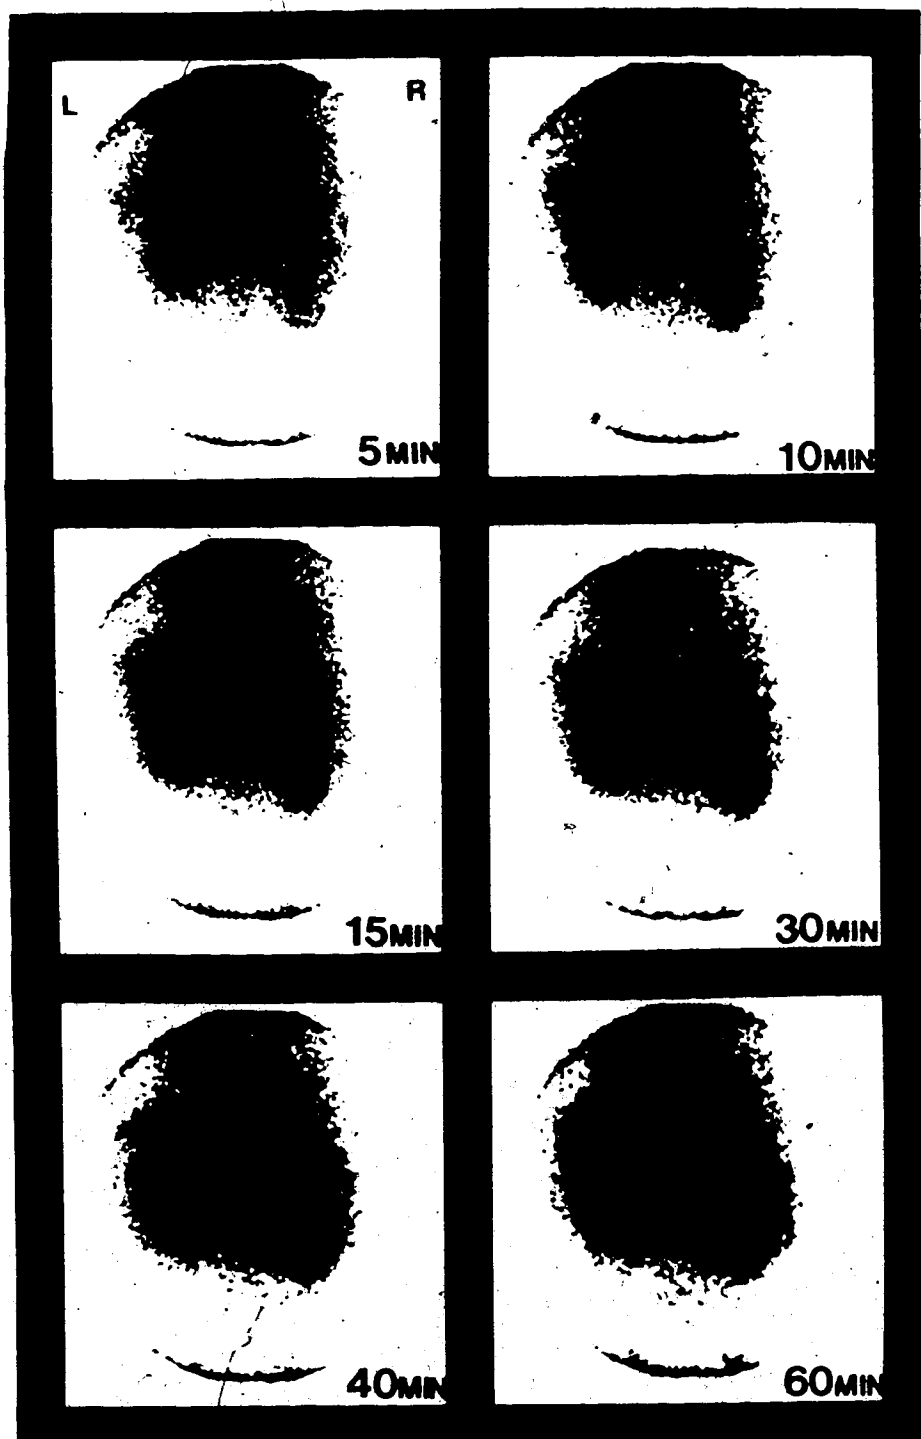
Typical Static ^{131}I -PNA renal scintigrams 0-60 min P.I. in humans.
